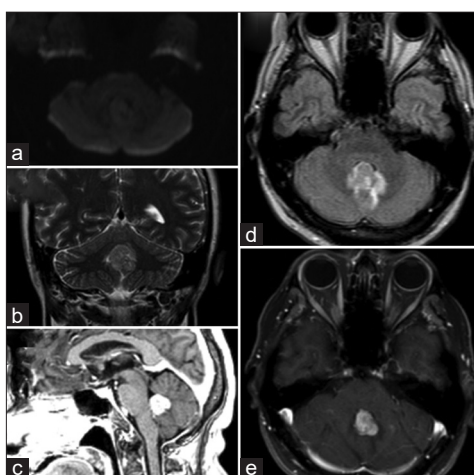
(a) Axial DWI shows no restriction of lesion. (b) Coronal T2 show high signal. (c) Sagittal T1 show high contrast uptake. (d) (Axial Flair) show high signal and (e) (Axial T1) show high contrast uptake
